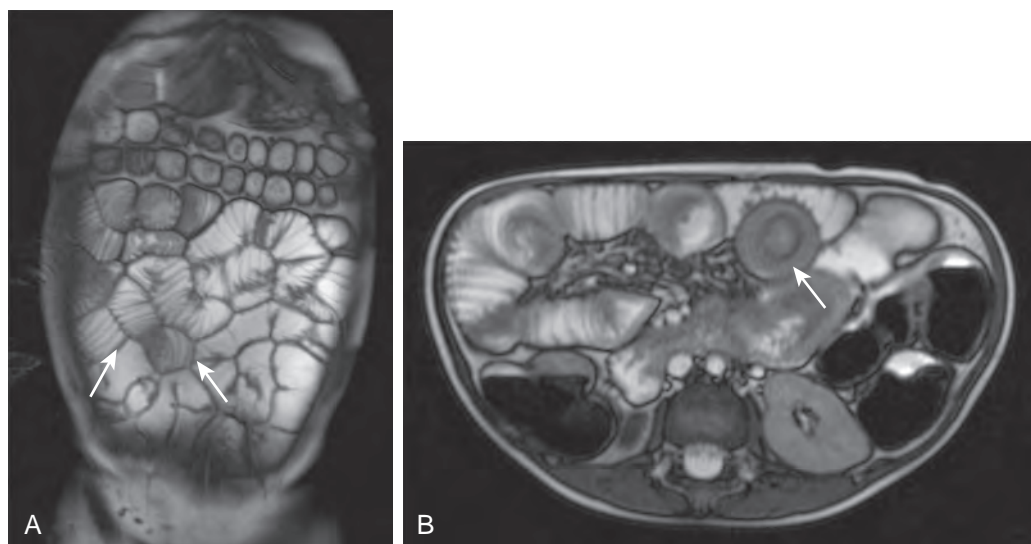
MR enterography of celiac disease in 25-year-old woman. A. T2-weighted coronal HASTE image shows increased number of folds along ileal loops (arrows), with normal fold pattern in the jejunum. B. T2-weighted HASTE axial image shows jejunojejunal intussusception (arrow).
